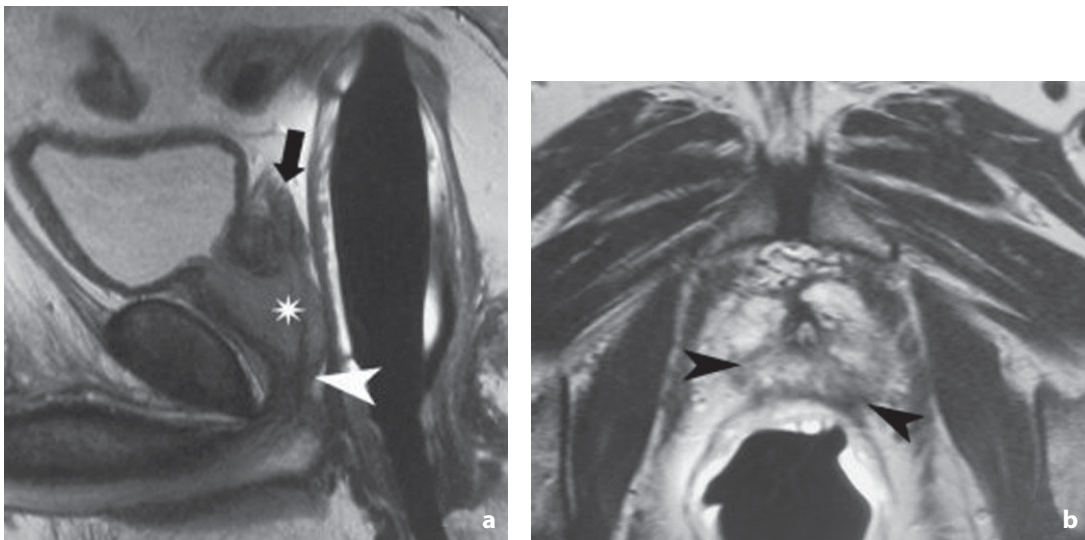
Magnetic resonance. Sagittal (a) and axial (b) T2-weighted images. Adenocarcinoma of the prostatic apex. The images show extensive tumor (*asterisk*) infiltrating the gland from the base to the apex (*arrowhead*) involving the seminal vesicles (*arrow*)
